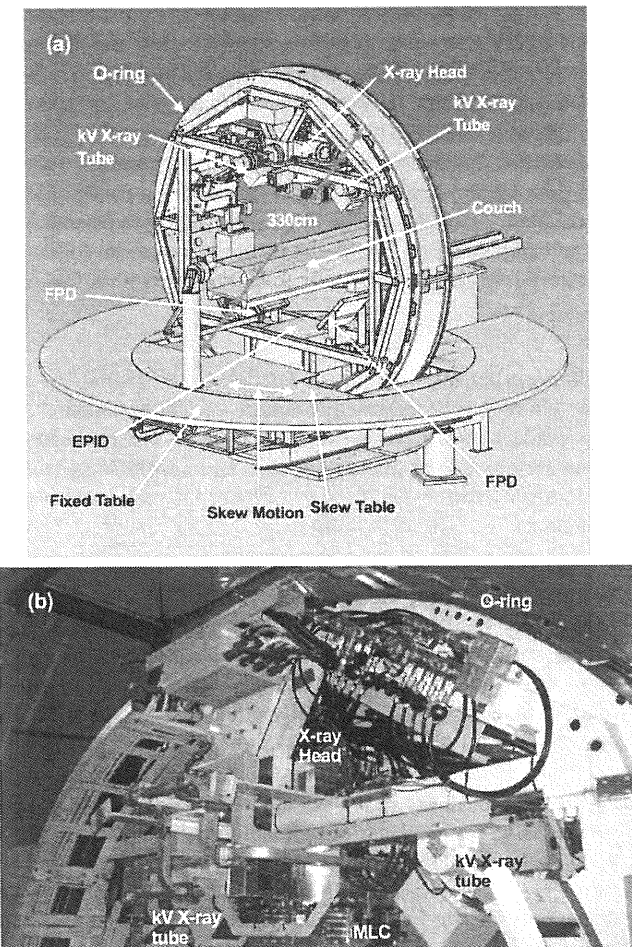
(a) The basic structure is the O-ring with diameter of about 330 cm. (b) The structure around the X-ray head is shown. The X-ray head is hidden behind the support structure and only the multileaf collimator (MLC) can be seen. The kV X-ray tubes are installed on the both sides of the MLC.
